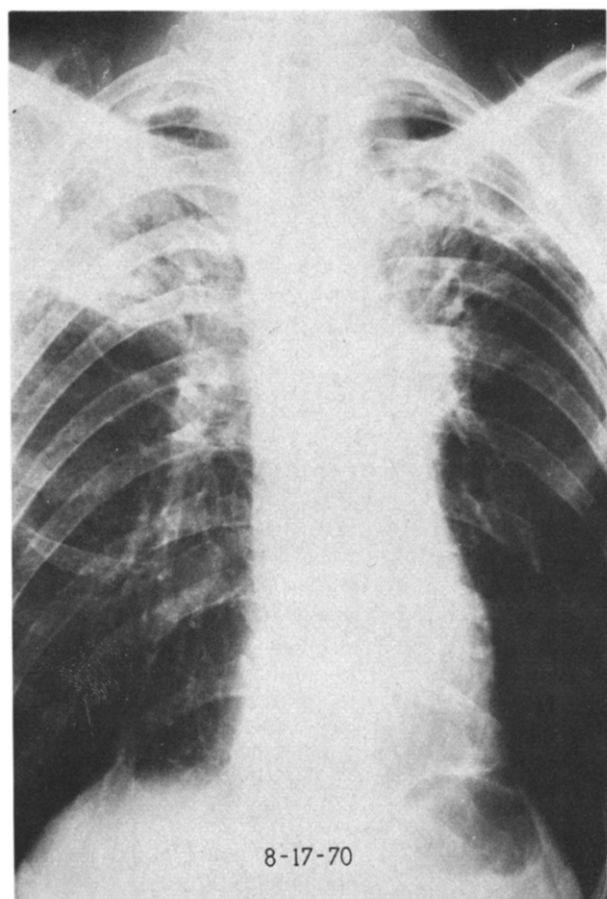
Case 2. Chest roentgenograms of August 17, 1970, taken after 6 weeks of fever and purulent sputum, showing cavitary lesion of upper lobe of left lung and acute pneumonic spread to upper lobe of right lung. Treatment with 5-fluorocytosine was instituted on August 31, 1970.
